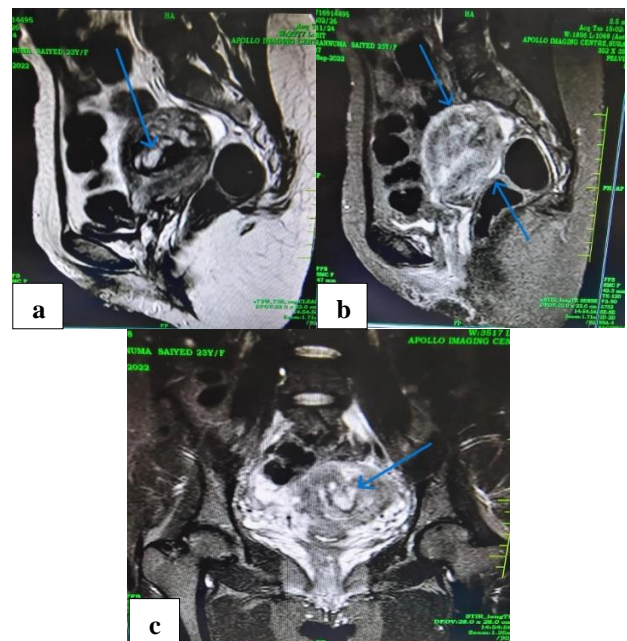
MRI images of 23 year old women who delivered 1.5 months back, (a) sagittal section suggestive of heterogenous irregular solid cystic lesion of T1 iso to hypointense lesion with few hyperintensities indicating bloody fluid in uterine cavity, most clearly indicating placental polyp, (b) T2 hypointense with few hyperintensities than myometrium clearly differentiating heterogenous tissue from debris and bloody contents, and (c) STIR hyperintense lesion with adherent heterogenous tissue to the myometrium.
